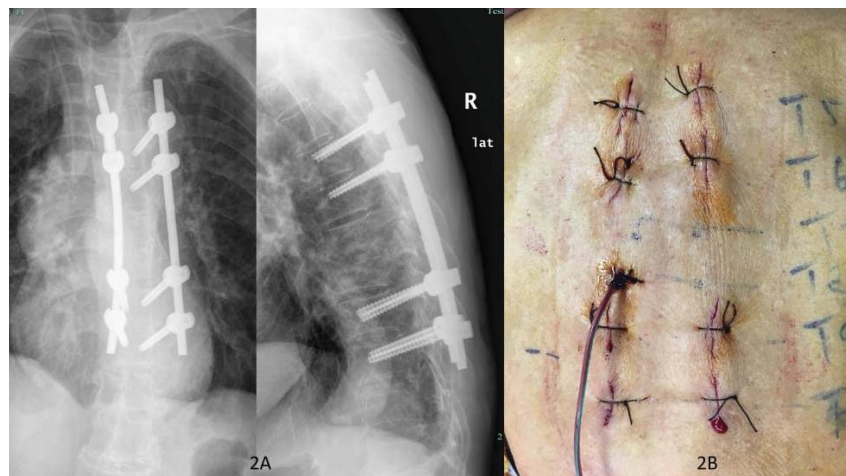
First operation was percutaneous pedicle screw fixation to reestablish the spinal stability. (A) Posteroanterior and lateral thoracic radiograph demonstrated the satisfactory screws and rods emplacement respectively. (B) A drainage tube was placed after biopsy on the left side of T8.
